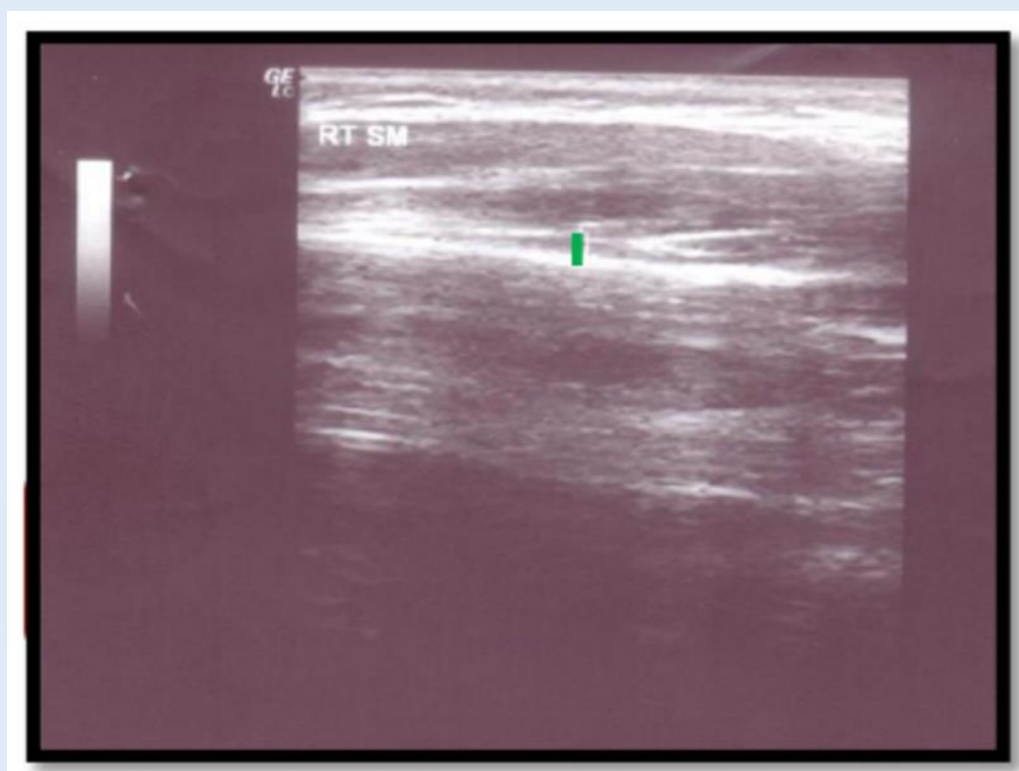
Post lycopene therapy diagnostic ultrasound.
